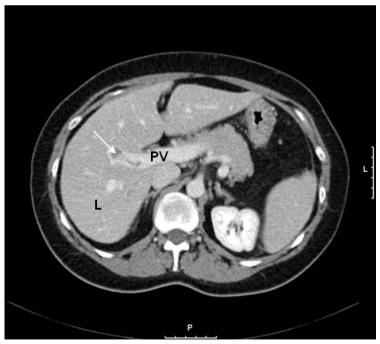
Computed tomography image of the liver (L) of a patient with portal vein thrombosis showing the presence of thrombotic material (arrow) in the lumen of the portal vein (PV).
